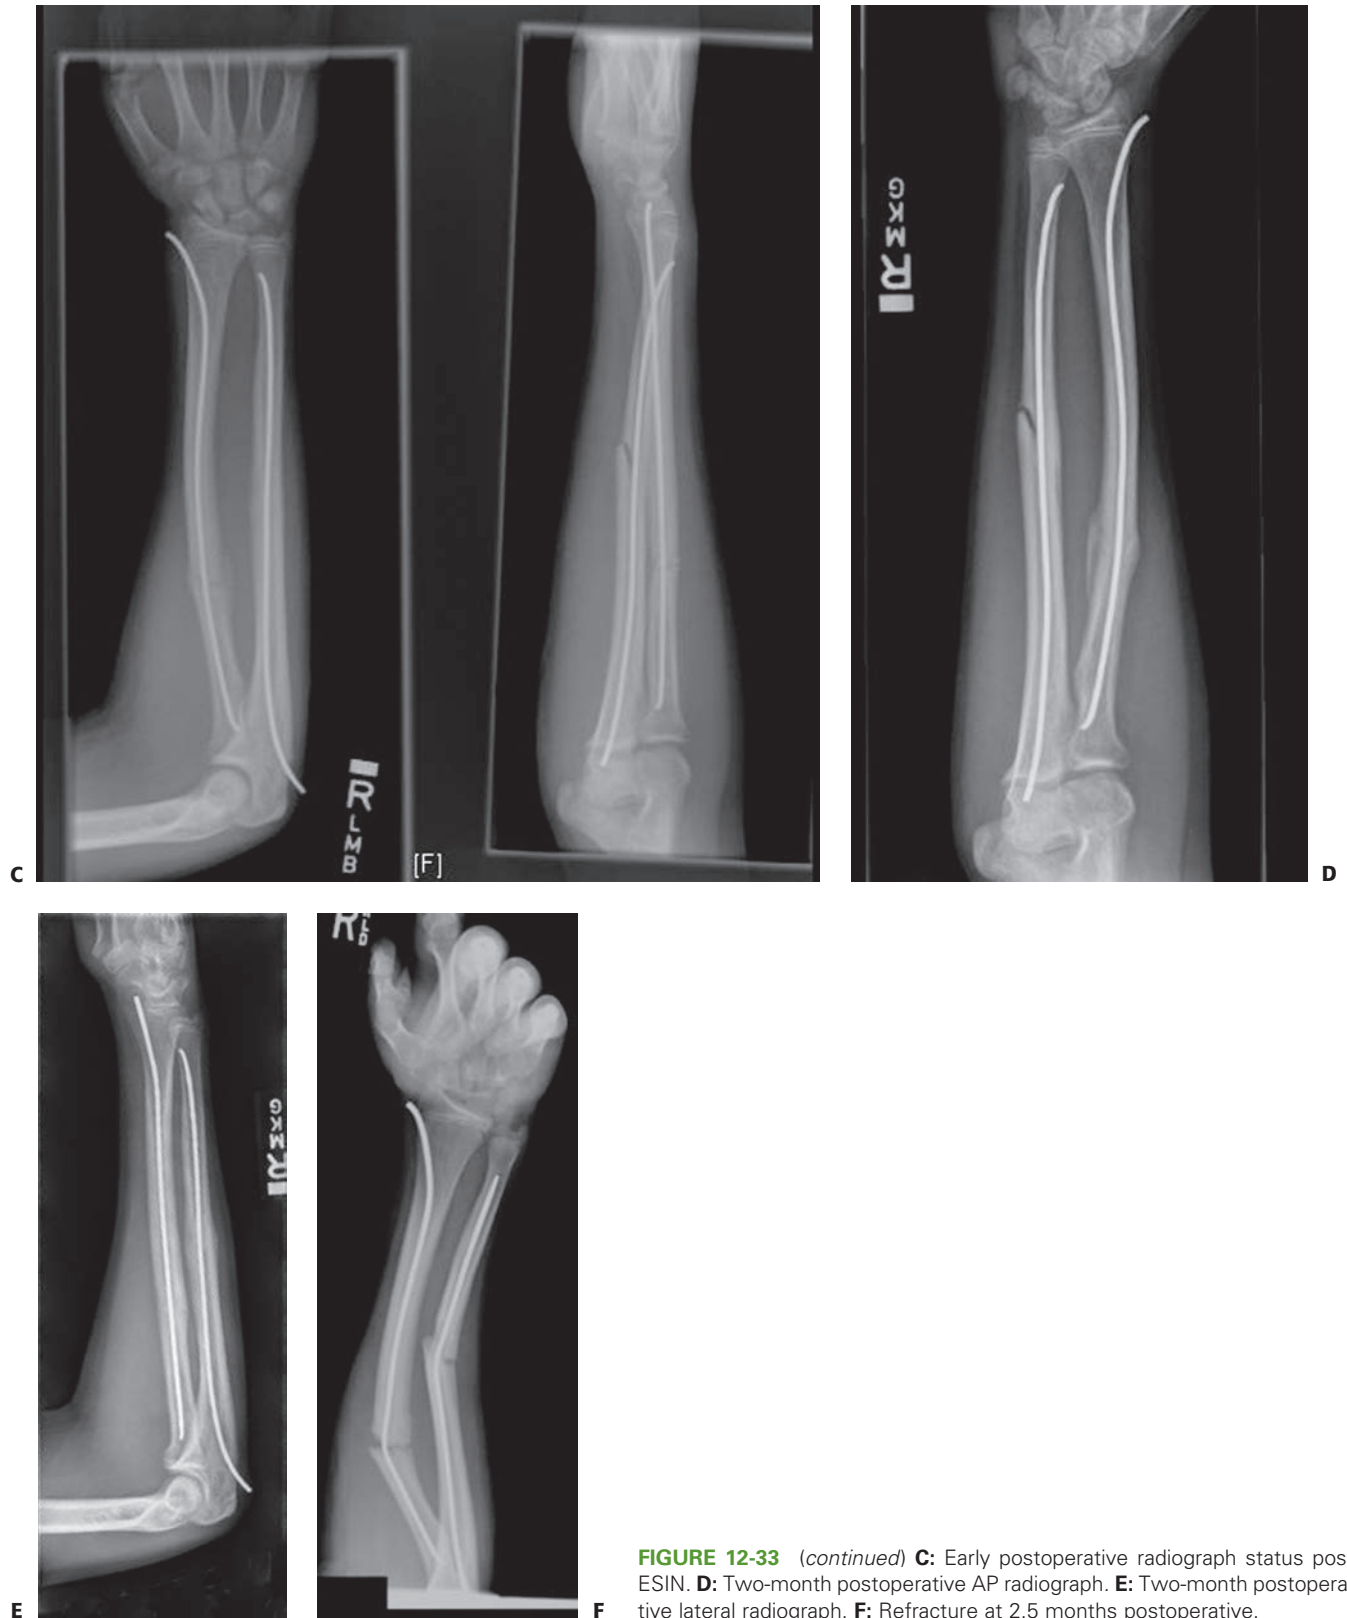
(continued) C: Early postoperative radiograph status post ESIN. D: Two-month postoperative AP radiograph. E: Two-month postoperative lateral radiograph. F: Refracture at 2.5 months postoperative.
